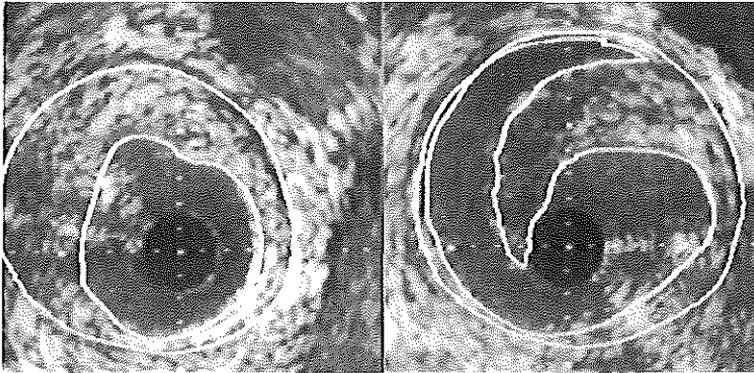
Corresponding intravascular ultrasound cross-sections obtained from a patient before and after balloon angioplasty (PTA) of the superficial femoral artery using the CVIS system. Before PTA (left), a soft eccentric lesion was involved; after PTA (right) a dissection was diagnosed. The extent of the arterial wall that was disease-free was 1 h (6 o'clock) and of the dissection, 4 h. The intravascular ultrasound cross-sections are contour-traced off-line for free lumen area (inner contour) and media-bounded area (outer contour). Calibration = 0.5 mm.
